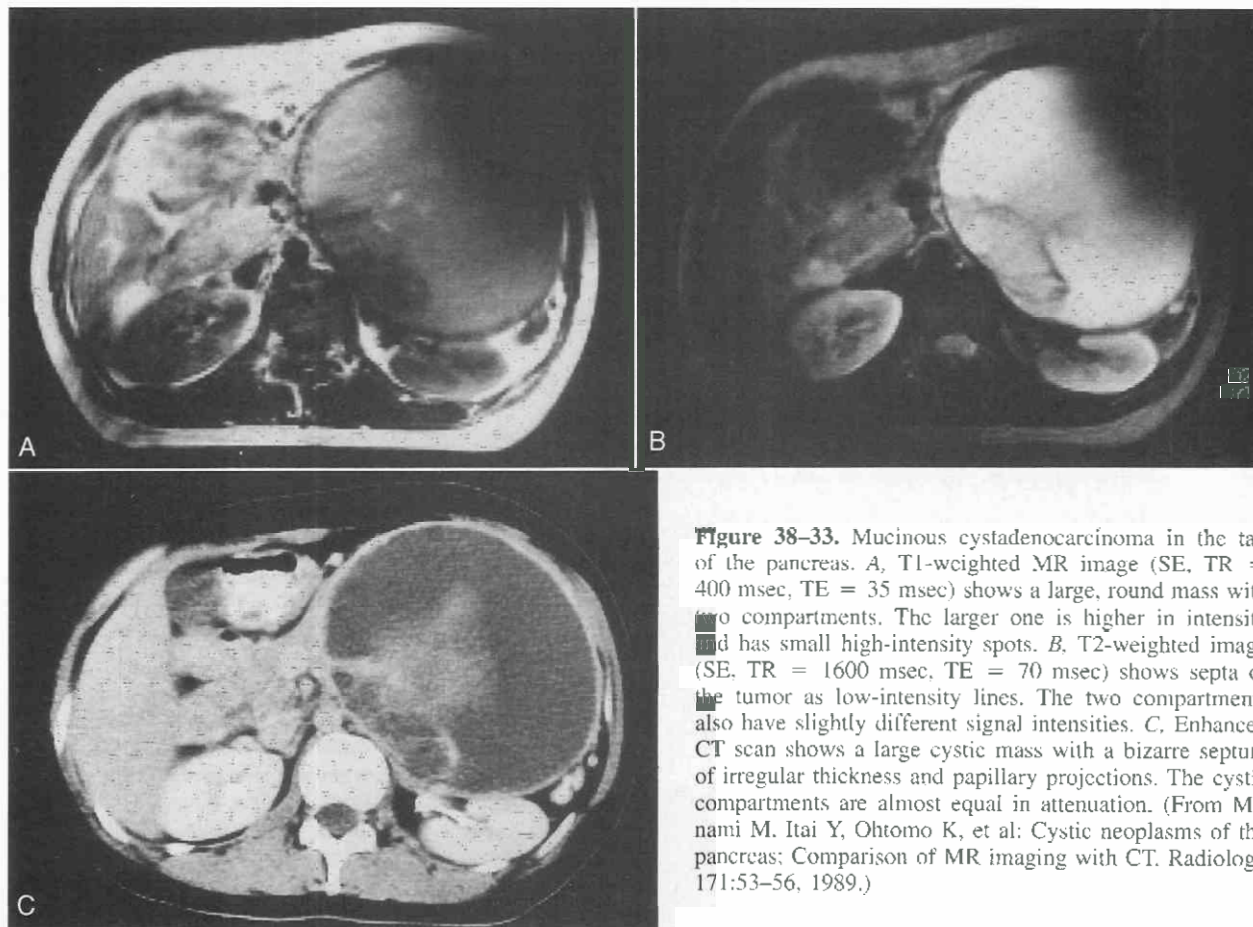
Mucinous cystadenocarcinoma in the tail of the pancreas. *A*, T1-weighted MR image (SE, TR = 400 msec, TE = 35 msec) shows a large, round mass with two compartments. The larger one is higher in intensity and has small high-intensity spots. *B*, T2-weighted image (SE, TR = 1600 msec, TE = 70 msec) shows septa of the tumor as low-intensity lines. The two compartments also have slightly different signal intensities. *C*, Enhanced CT scan shows a large cystic mass with a bizarre septum of irregular thickness and papillary projections. The cystic compartments are almost equal in attenuation. (From Minami M, Itai Y, Ohtomo K, et al: Cystic neoplasms of the pancreas: Comparison of MR imaging with CT. *Radiology* 171:53-56, 1989.)
